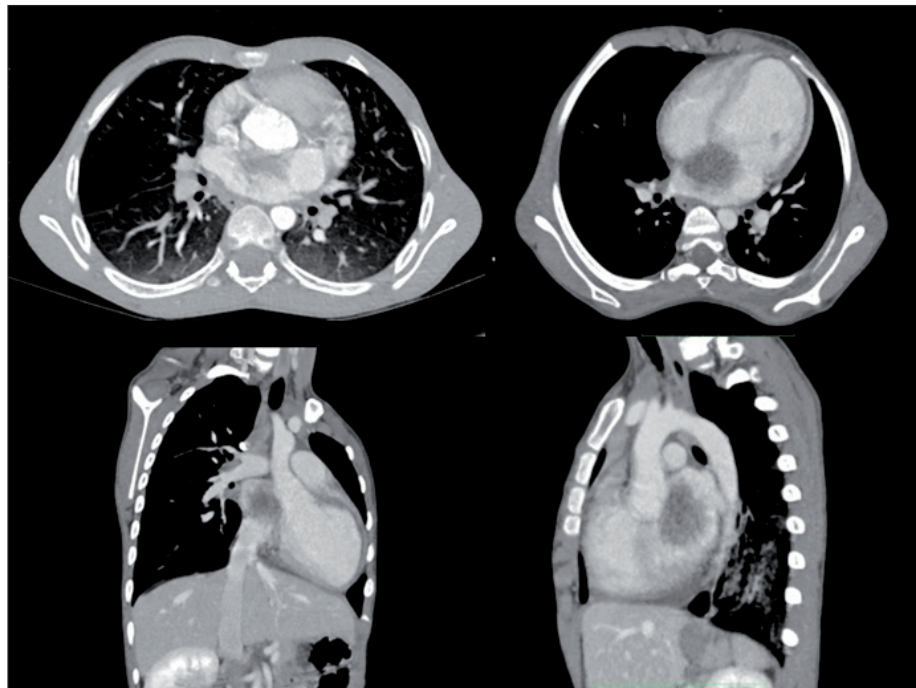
Different acquisitions on thoracic CT scan showing an intracardiac mass.
